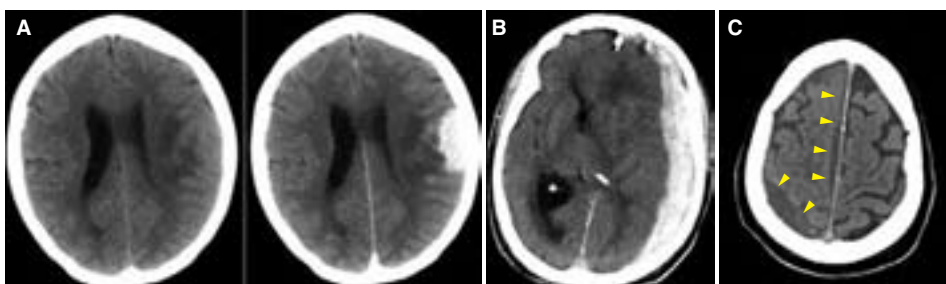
Dura mater. A. Images with and without contrast medium. Meningioma with a wide base on the convexity dura. B. Subdural haematoma extending along the dural surface of the hemisphere. C. Post contrast CT image with a subdural empyema indicated by arrowheads. Note compression of the subarachnoid spaces.
